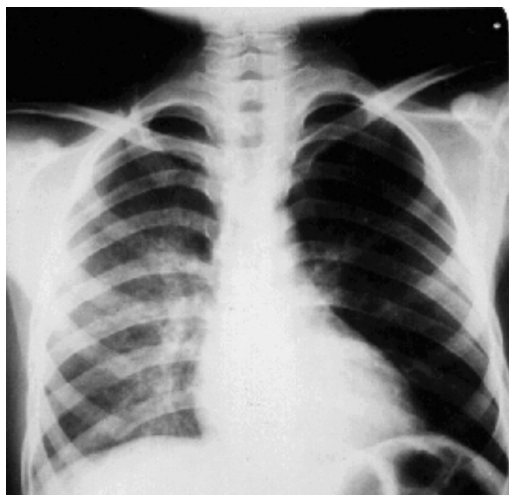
Chest x-ray taken at discharge from the hospital six days after the sting revealing significant improvement of asymmetric pulmonary edema.
